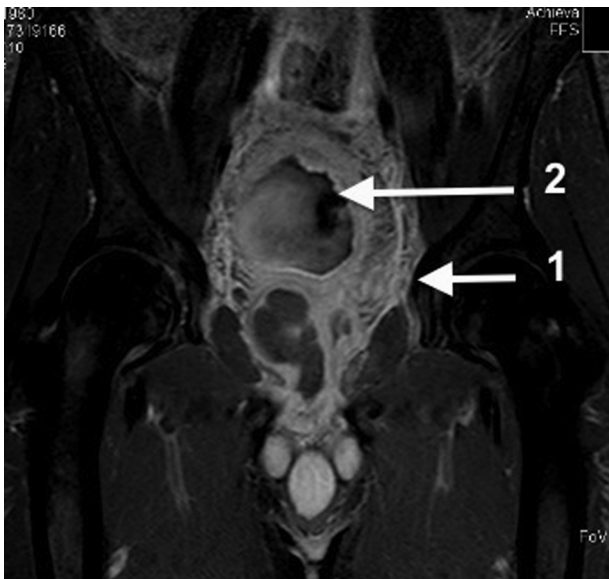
Abdominal and pelvic MRI. 1, pelvic varicose veins; 2, circumferential thickening of the bladder wall.
